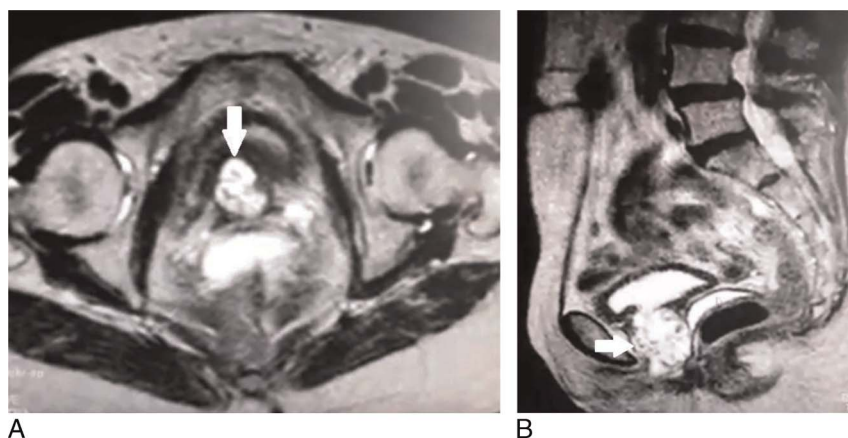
A. Axial MRI image of pelvis with arrow indicating urethral tumor. B. Sagittal MRI image of pelvis with arrow indicating urethral tumor. MRI, magnetic resonance imaging.
